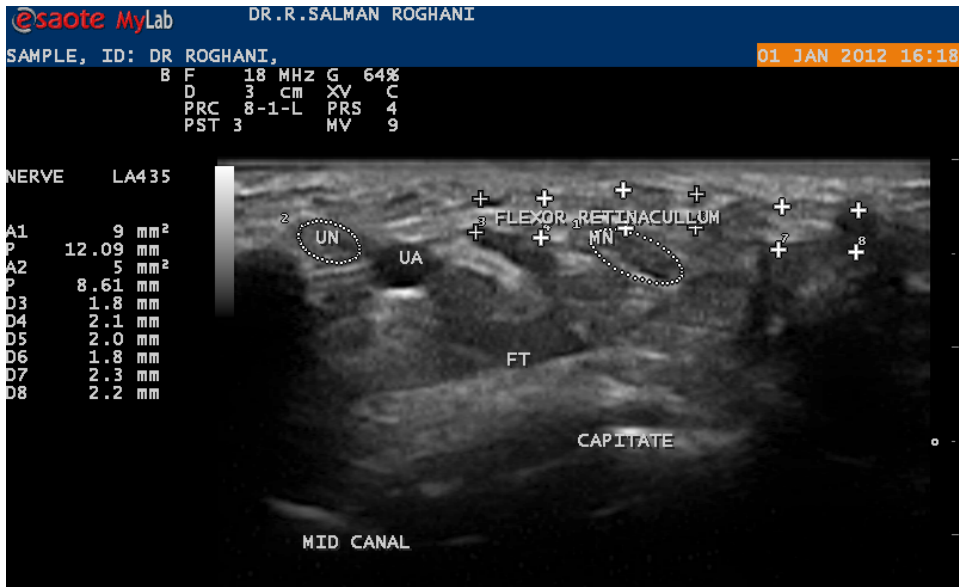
Ultrasound cross sectional Image at the tunnel of carp with a lot of anatomic information about region(The author<sup>2</sup> personal archive)
